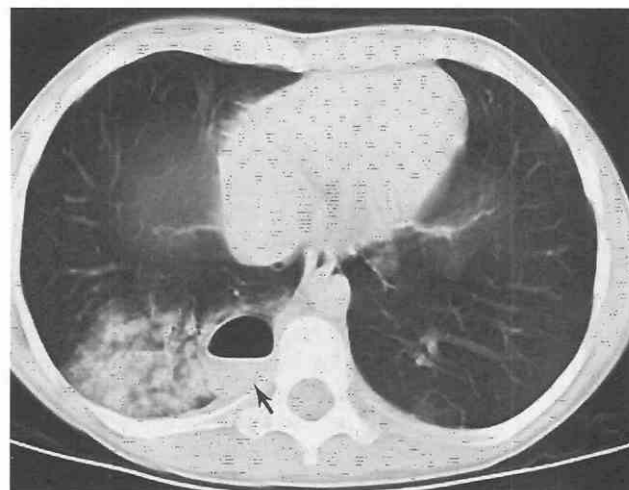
Pulmonary laceration in a 10-year-old girl who fell out of a tree. CT scan shows consolidation within the posterior right lower lobe with an associated parenchymal cavity (arrow) containing an air-fluid level.
